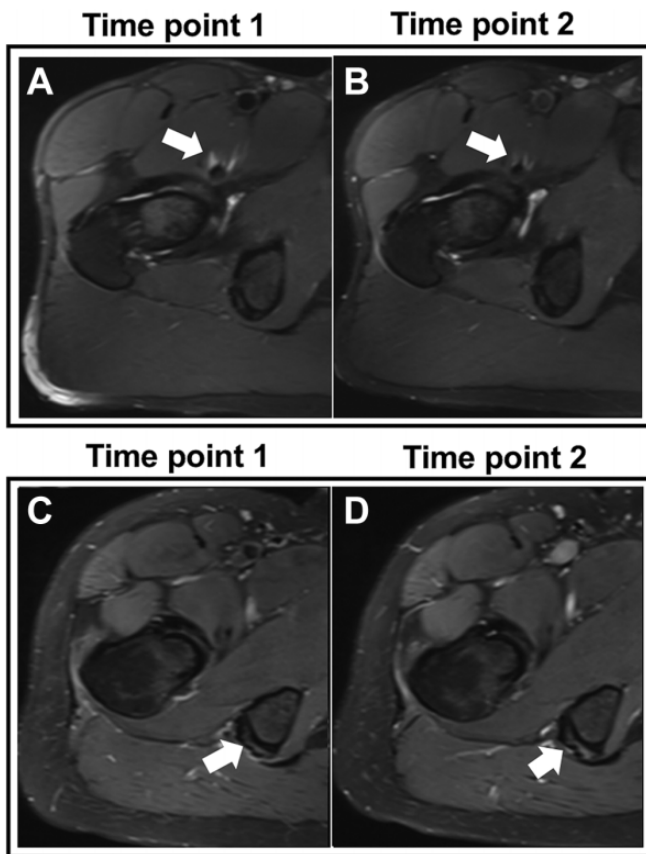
Axial Dixon magnetic resonance imaging scans of 2 participants showing tendinosis at time point 1 and no worsening at time point 2. (A, B) Participant 1 had psoas tendinosis (arrows). (C, D) Participant 2 had hamstring tendinosis (arrows).
